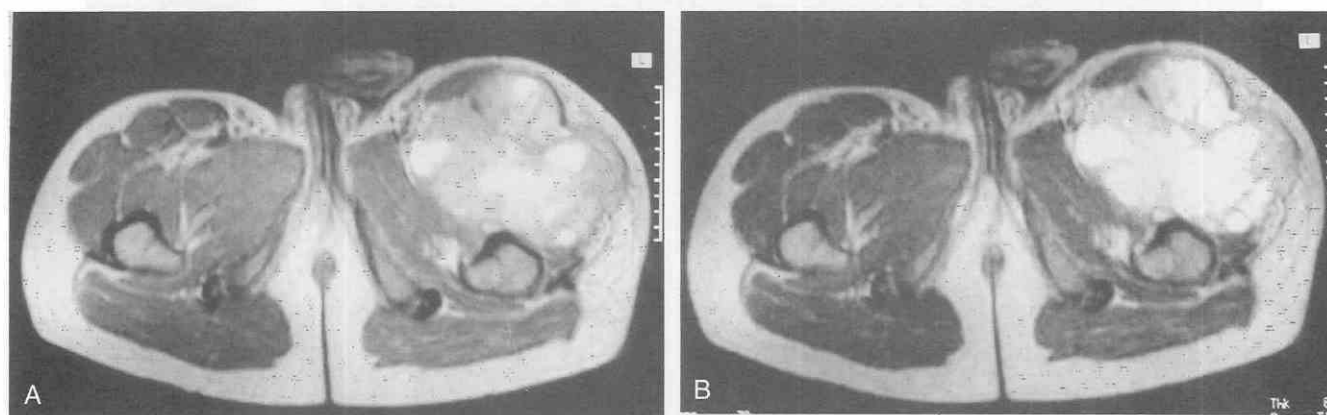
Synovial sarcoma. A, Axial proton-density image reveals intermediate to high signal intensity. B, Axial T2-weighted image reflects heterogeneous high signal intensity.
